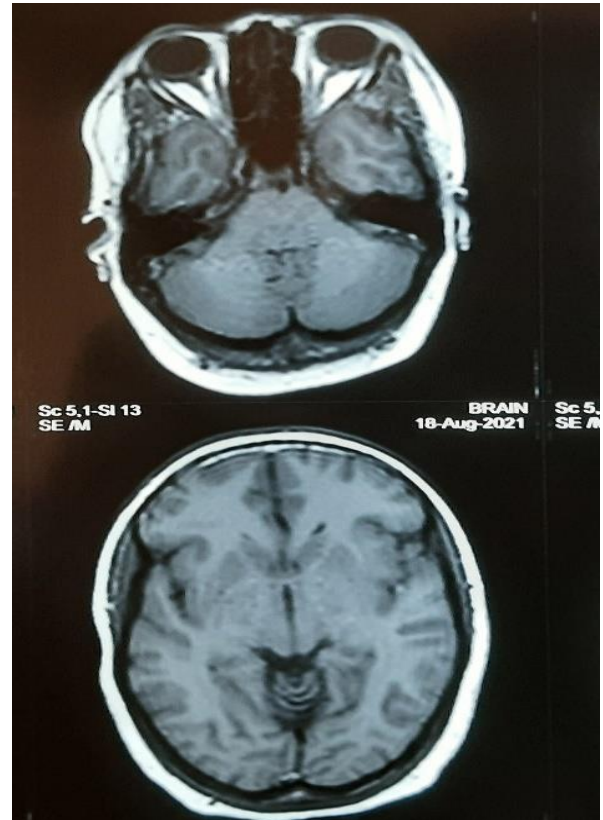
MRI Head and Orbit with normal findings in the study subject
